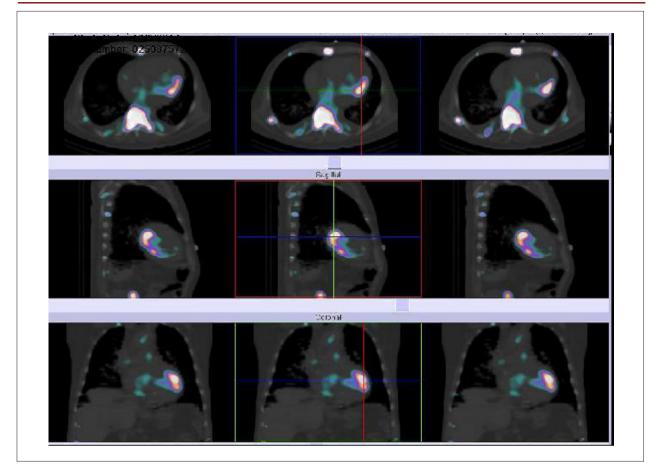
4 - hours SPECT/CT of chest showing hyperfixation of ^{99m}Tc-pyrophosphate radiotracer in cardiac basal lateral segment, suggestive of acute myocardial infarction in healing stage.
